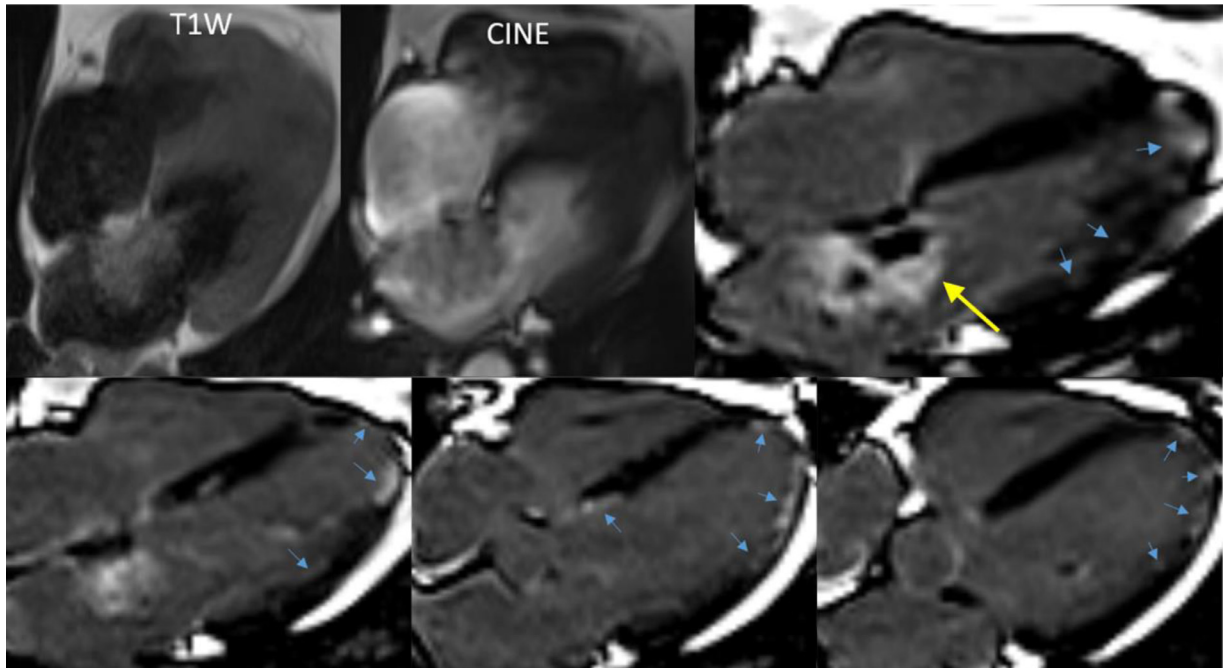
Contrast-enhanced cardiac MRI showing a mass with an intermediate signal on T1-weighted sequences, hyperintense on cine SSFP compared to normal myocardium, and exhibiting late gadolinium enhancement. The central areas that demonstrate no enhancement correlate with hemorrhagic breakdown products (yellow arrow). Late CMR images showing multiple small myocardial scars as separate and randomly distributed lesions (blue arrow).
